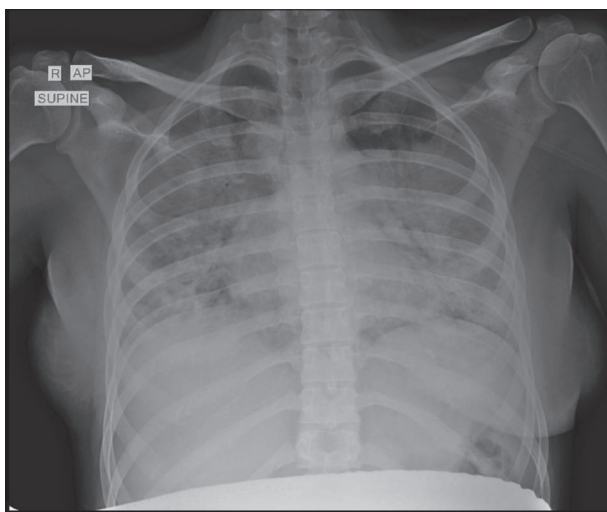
X-ray of the patient's heart and lungs seven days after the administration of two doses of tocilizumab; compared to the previous chest X-ray, there is slightly increased transparency in the right lung and lower part of left lung due to a mild regression in the density of merged consolidations, accompanied by a less pronounced air bronchogram and a more clearly outlined hemidiaphragm – all consistent with mild regression
